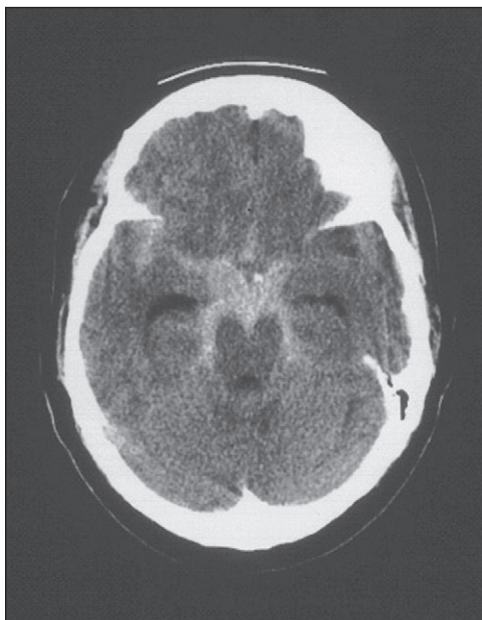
Cerebral aneurysm. Shown is a computed tomography scan of an aneurysmal subarachnoid hemorrhage in a 55-year-old woman. Subarachnoid blood can be seen within the interpeduncular and ambient cisterns and the right sylvian fissure, from a ruptured aneurysm at the junction of the right carotid artery and the posterior communicating artery. (From Soliman E, Kader A, Perez N: Cerebral aneurysm. Online article at eMedicine.com. Available at <http://www.emedicine.com/med/topic3468.htm>, picture 8.)
